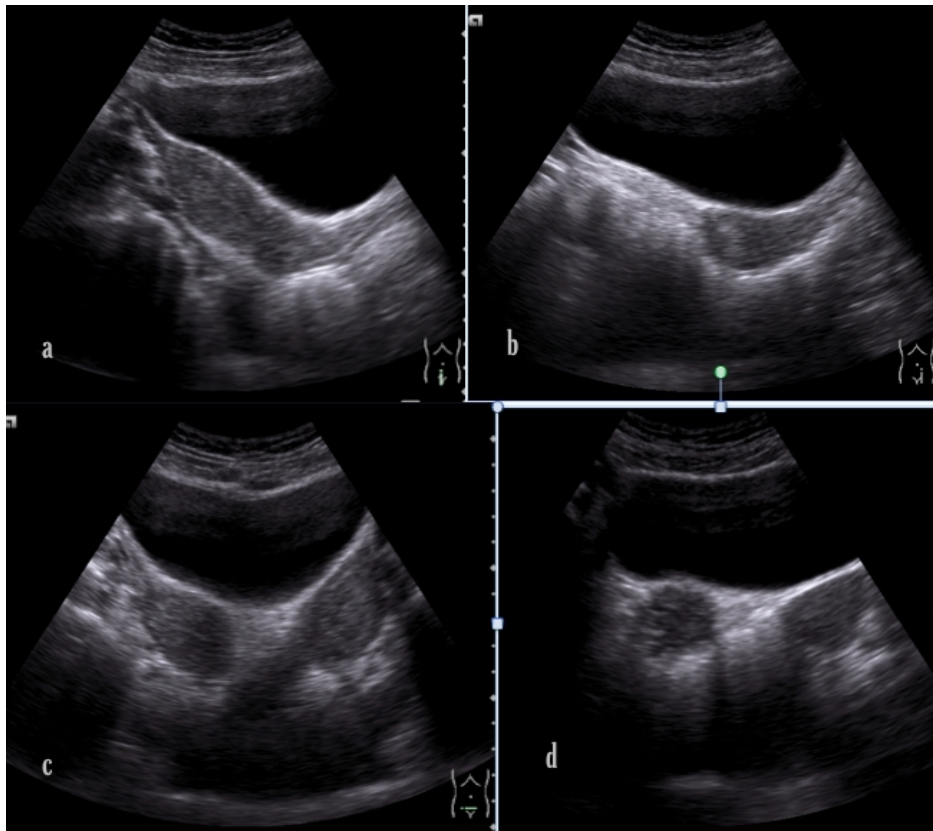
Ultrasound images of 23 years old female who came with pain in abdomen and bleeding per vaginum. Fig. 1 a shows large right uterus and b shows small left uterus in longitudinal plane. Figs. 1c and 1d show two separate uterine bodies and cervixes in transverse plane
